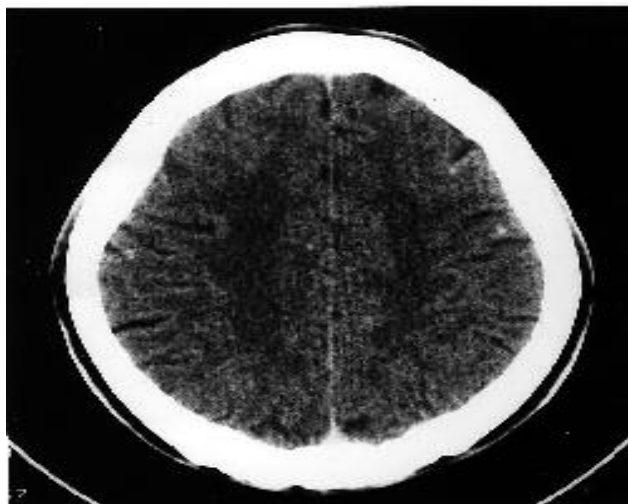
Non enhancing CT scan showing multiple calcified cysts in a patient who presented with seizures.
